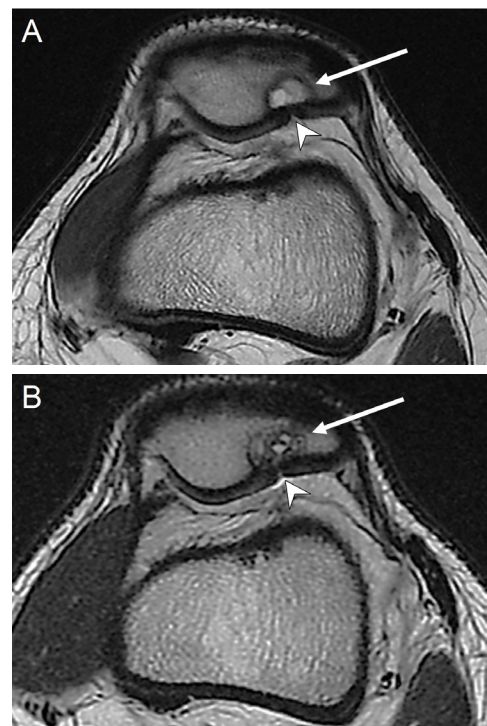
Axial T2W images of the left knee at the time of presentation (A) and at follow-up MRI 1 year later (B).
